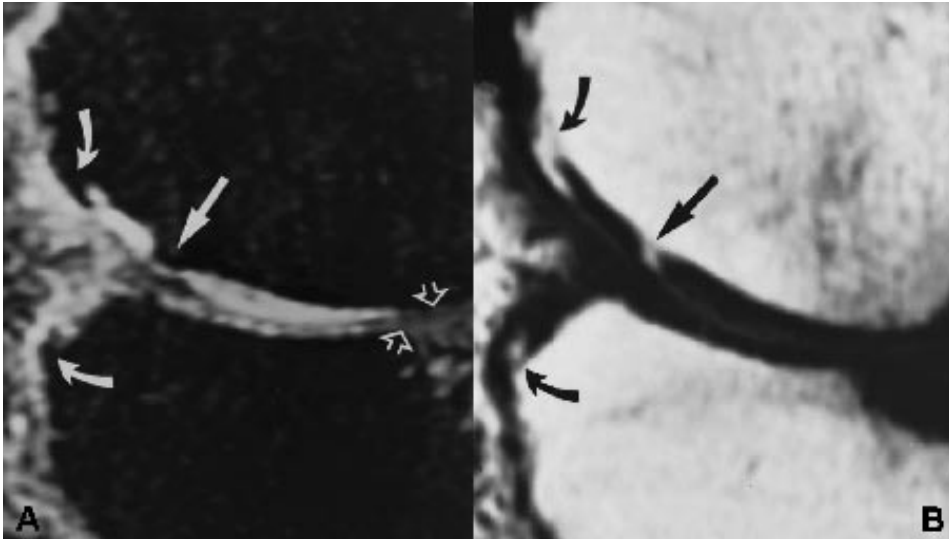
A B 59-year-old woman with central osteophyte at medial femoral condyle that fills base of articular cartilage defect. A, Sagittal fat-suppressed three-dimensional spoiled gradient-echo MR image (TR/TE, 40/6; flip angle, 40°) shows central osteophyte (solid straight arrow) and marginal osteophytes (curved arrows). Full-thickness articular cartilage defects (open arrows) that are separate from central osteophyte can be seen at femoral condyle and tibial plateau along with subchondral signal abnormality beneath tibial plateau defect. B, Sagittal T1-weighted MR image (600/14) shows central osteophyte (straight arrow) and marginal osteophytes (curved arrows) with fat signal from marrow extending into osteophytes.
